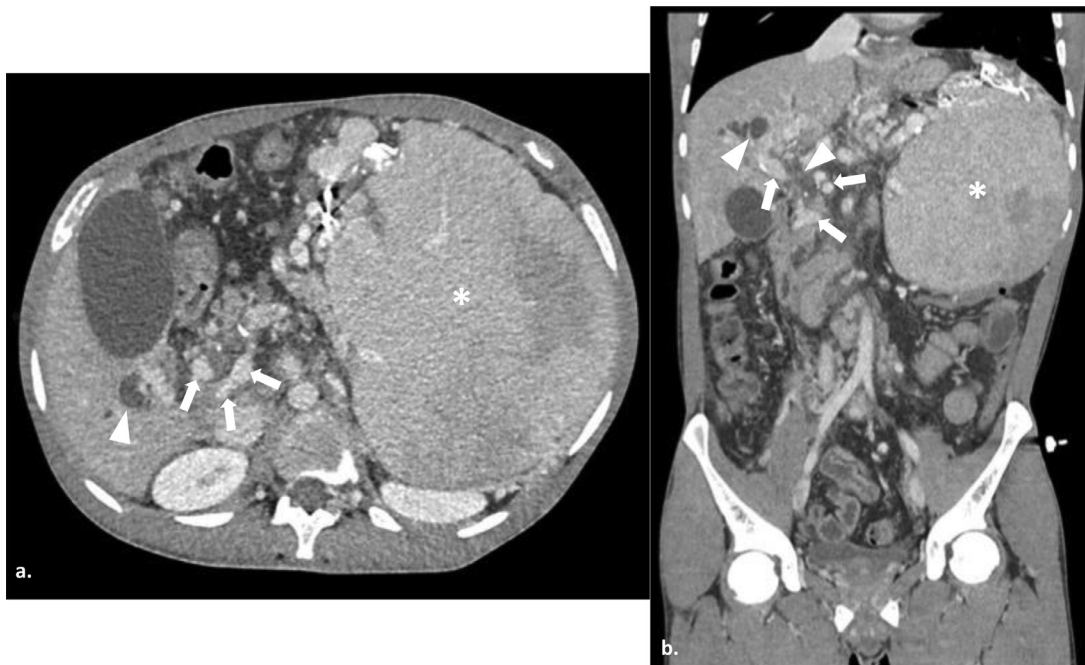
Axial (A) and coronal (B) contrast-enhanced portal phase CT scan of the abdomen, demonstrating cavernomatous transformation of the portal vein with multiple varicose venous collaterals at the hepatic hilum causing compression on the common bile duct and a proximal dilatation of the biliary tree (white arrowheads in a and b). Notice the severe splenomegaly (asterisks in A and B).
